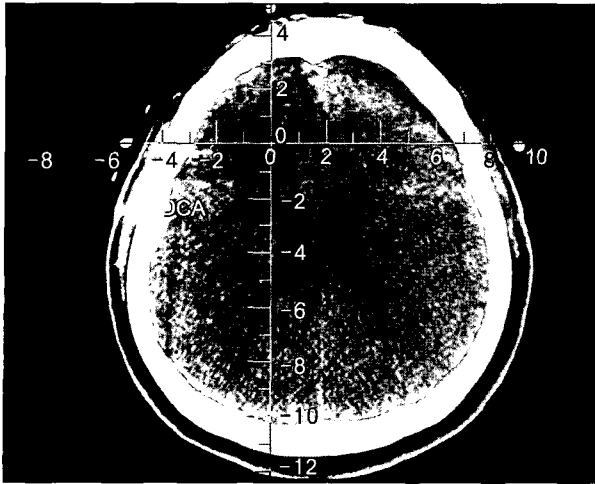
Postoperative CT image shows complete removal of the tumor in the right frontal lobe.
